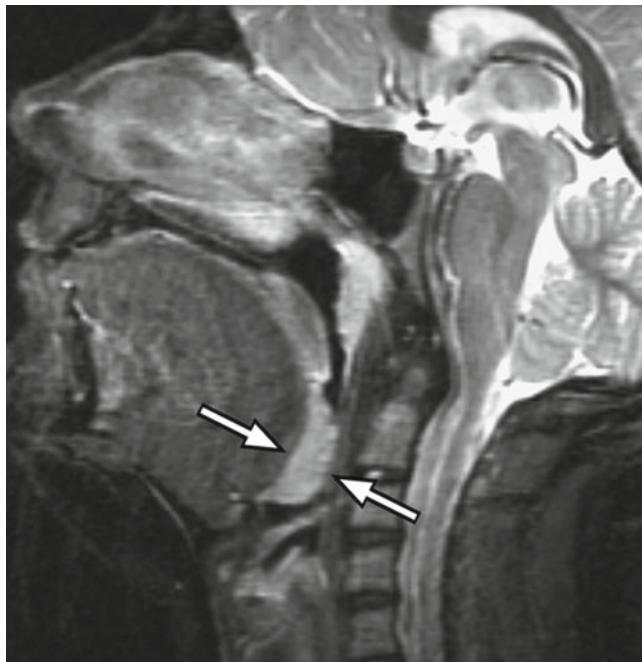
Lingual tonsil hypertrophy: Sagittal magnetic resonance imaging (MRI) depicting hypertrophy (arrows) of the lingual tonsils and narrowing of the hypopharyngeal airway
